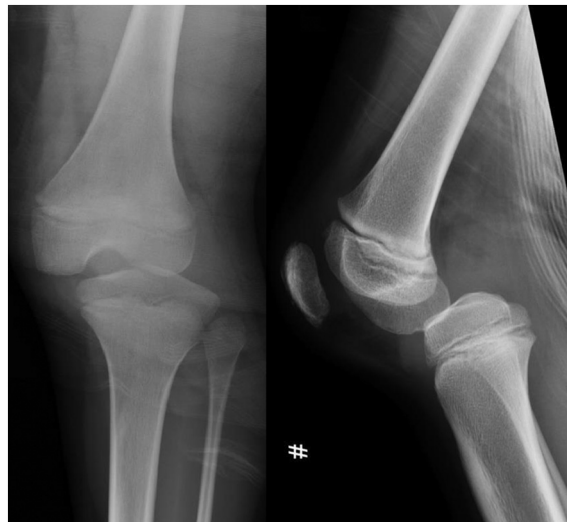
Antero-Posterior (AP) and lateral radiographs at initial presentation immediately after Judo injury.
